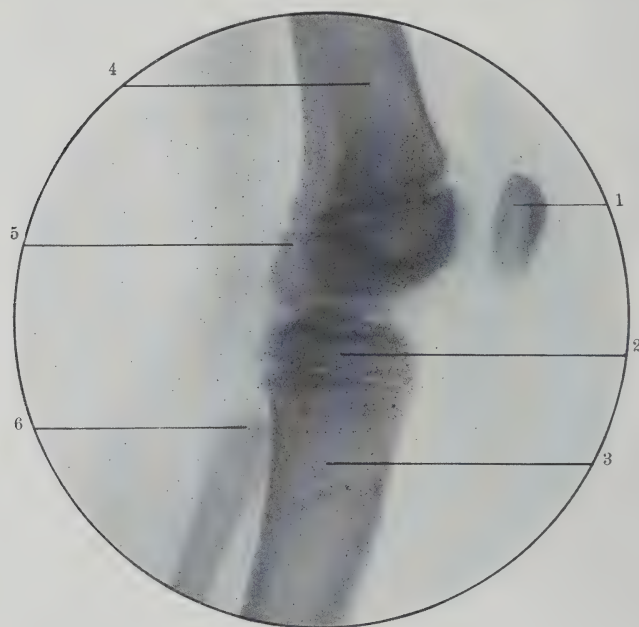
Radiograph Showing Lateral View of Knee Joint at Seven Years. 1, Patella; 2, upper epiphysis of tibia; 3, tibia; 4, femur; 5, lower epiphysis of femur; 6, upper epiphysis of fibula. (Original.)
